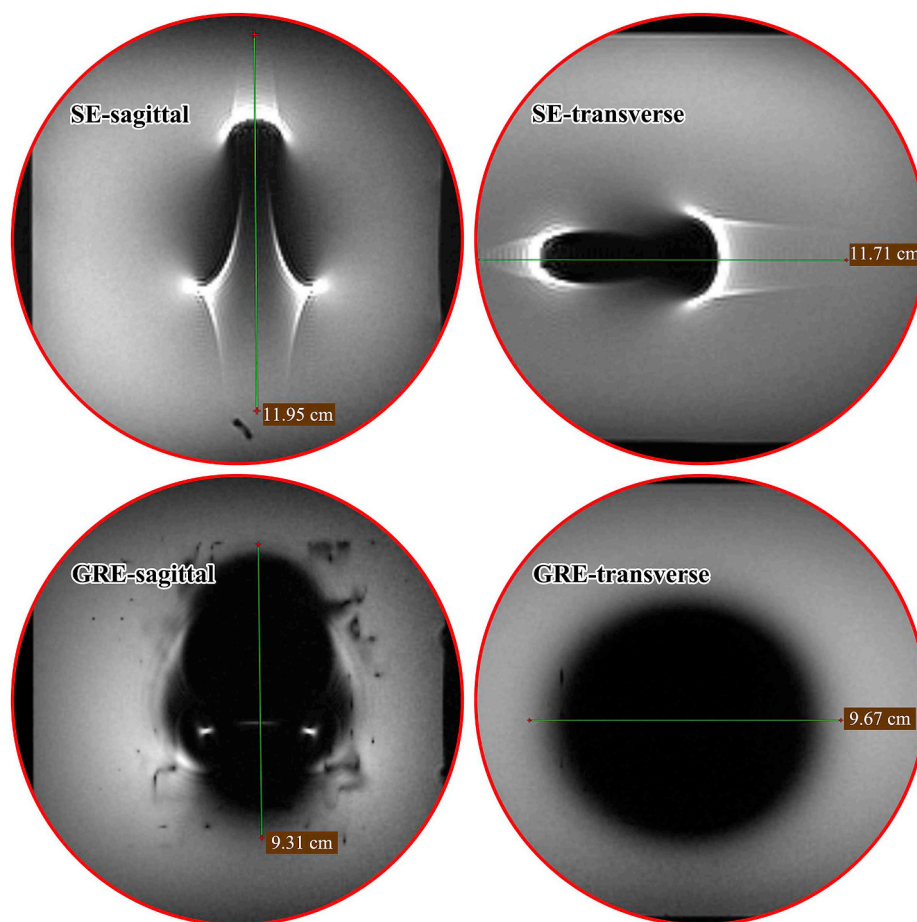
Typical MR images showing how the image artifact width was measured in the directions of transverse and sagittal planes (the scaffold was placed perpendicular to the main magnetic field).
